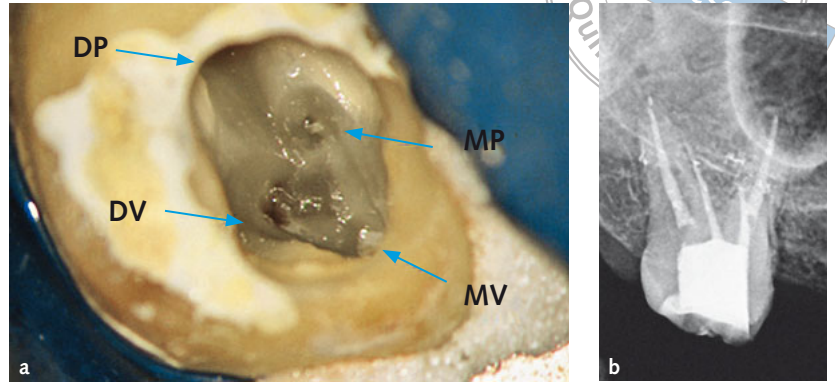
Clinical aspect of the pulp chamber floor during the intracanal diagnosis (a) and the control radiograph following root canal filling of the molar presented in Fig 2.
